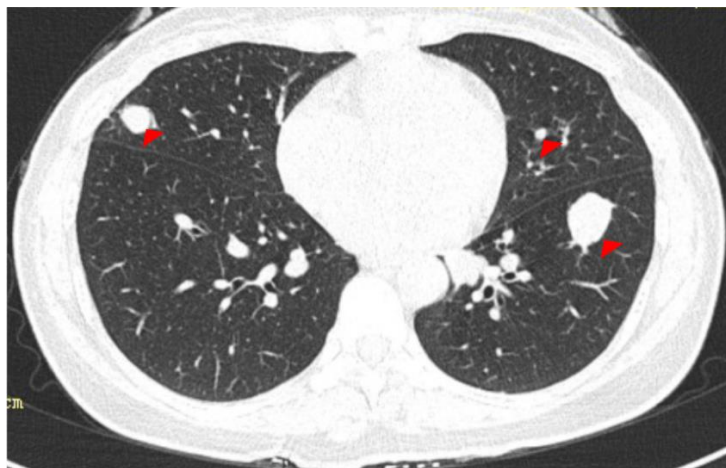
A CT scan image of the chest during follow-up 8 months after diagnosis
